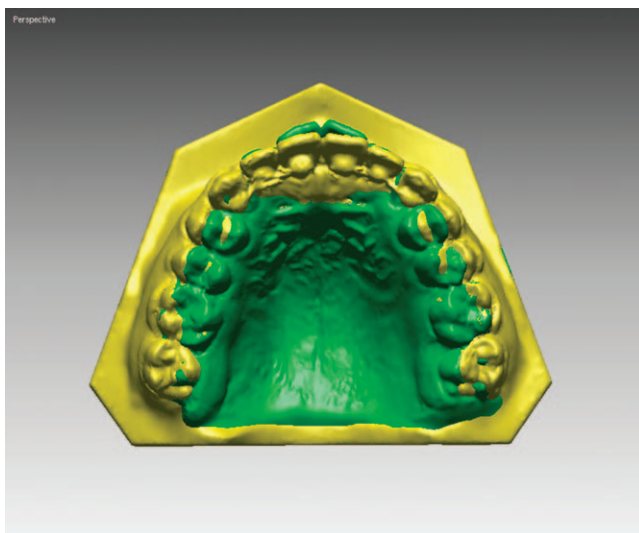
Superimpositions of computed tomography surface scan image (dark gray color: pretreatment; light gray color: posttreatment).
